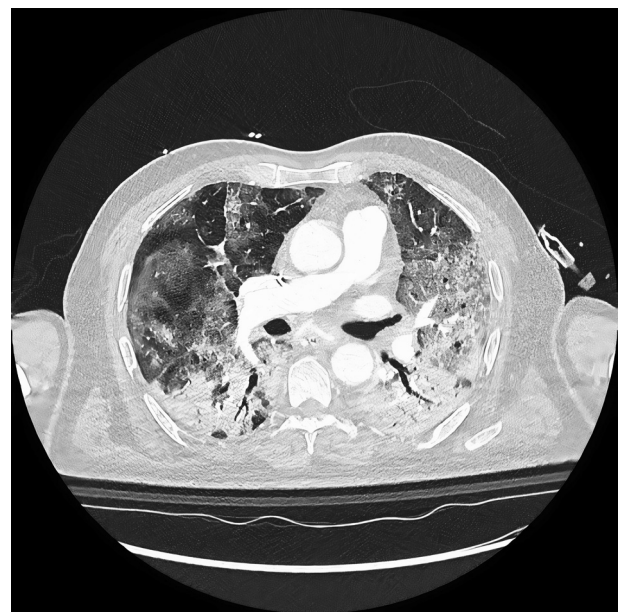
Same patient as in Fig 1. CT of the chest (lung window: width 1600 HU/length -500 HU) in the axial plane shows critical lung involvement.
